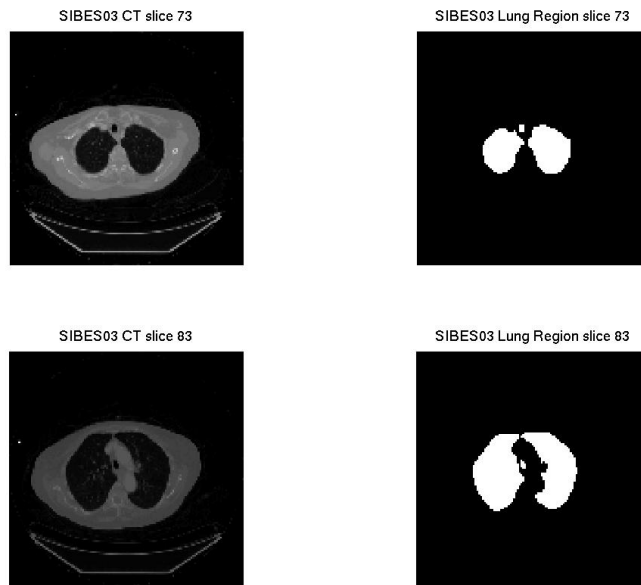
Two CT slices and their corresponding segmented lung region.*
